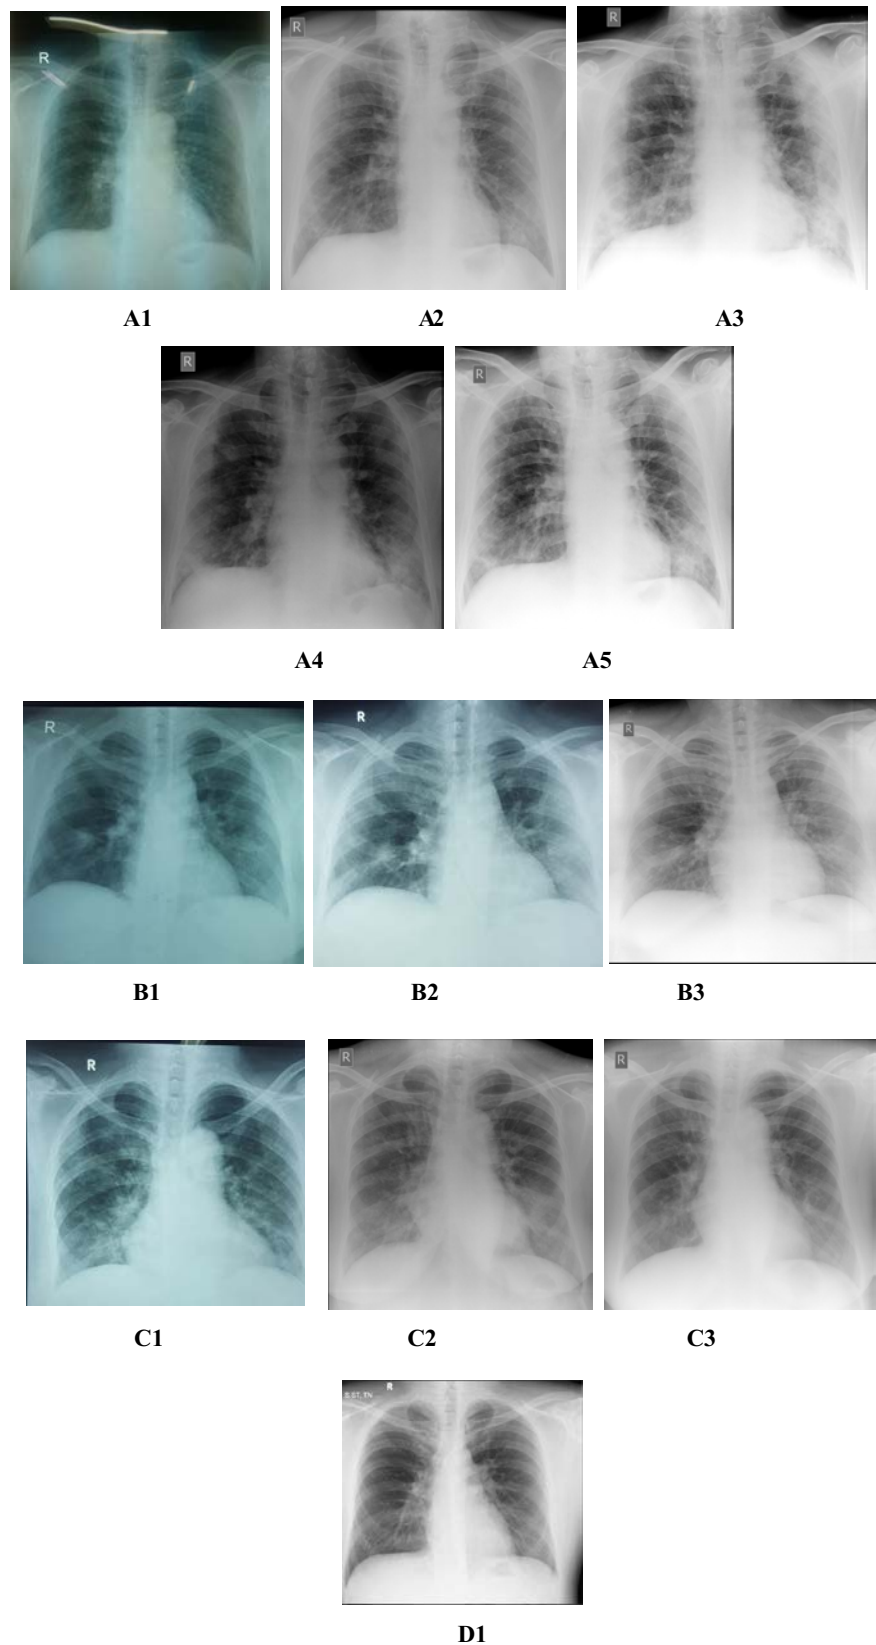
Chest radiograph of all patients. A. Patient 1; B. Patient 2; C. Patient 3; D. Patient 4; A1. 7th April 2020; A2. 9th April 2020; A3. 10th April 2020; A4. 20th April 2020; A5. 1st May 2020; B1. 7th April 2020; B2. 9th April 2020; B3. 17th April 2020; C1. 9th April 2020; C2. 14th April 2020; C3. 20th April 2020; D1. 10th April 2020).
